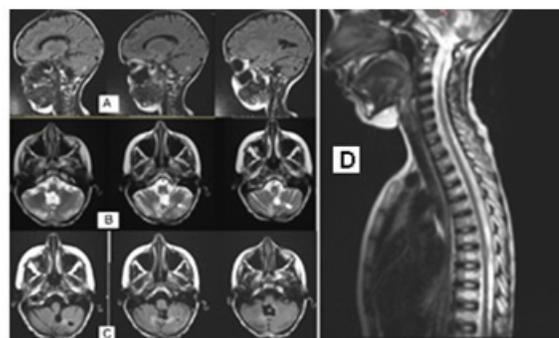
MRT/ March 2022- A second inoperable local recurrence without craniospinal leptomeningeal metastases - A/Sag T2 FLAIR; B/ Ax T2 fr FSE; C/ Ax T2 FLAIR; D/ Sag T2 fr FSE.
